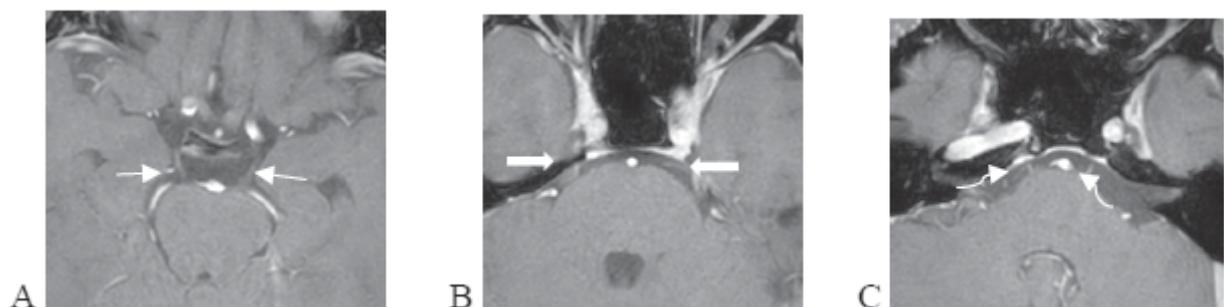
Case 6: Miller-Fisher syndrome (MFS): A 28-year-old male presented with diplopia, limb weakness and visual loss for 1 day. Axial MRI of the brain and orbits post gadolinium T1WI shows enhancement along cisternal portion of bilateral CN III (A, white arrow), CN V (B, white thick arrow) and CN VI (C, curve arrow).
